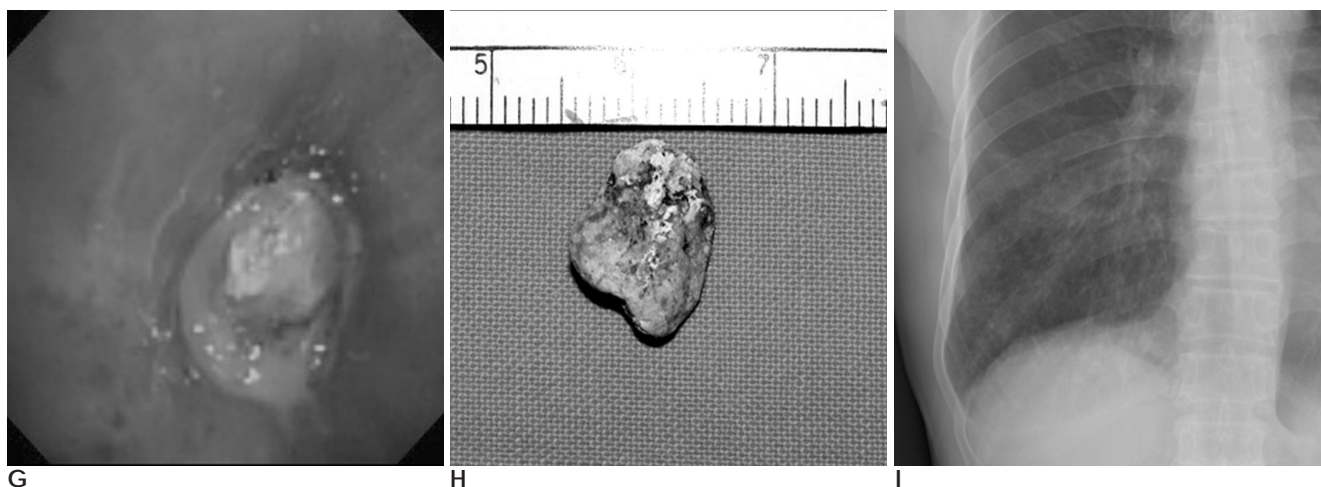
A. Chest radiograph shows peribronchial infiltrates in right lower lung zone. Note radiopaque oval density in right lower lobar bronchus (arrow). There is incidental fibronodular tuberculosis scar in right upper lobe.
